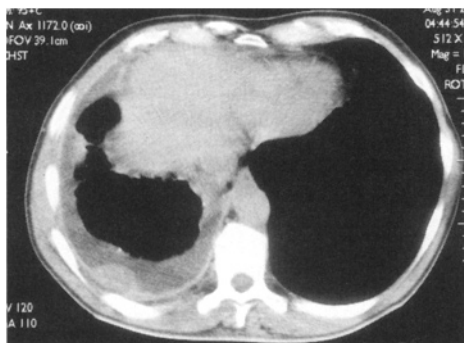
CT scan: 66 year old man with sarcomatous mesothelioma. There is a right pleural effusion, diffuse thickening of the parietal pleura but also a localised well defined tumour mass
